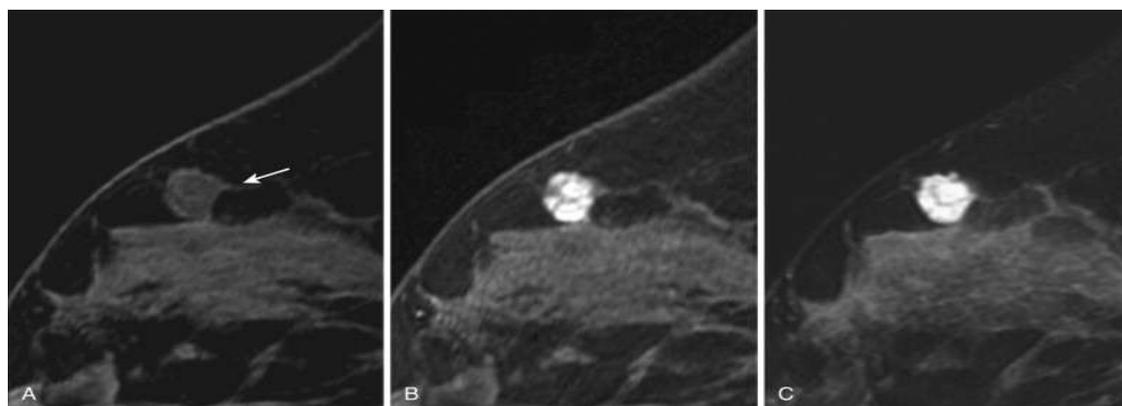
MRI of breast fibroadenoma
